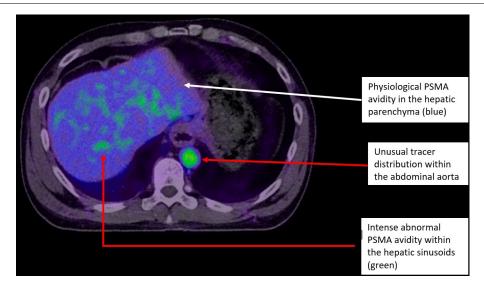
An axial section of AM's PSMA PET scan demonstrating intense tracer presence (green) within the hepatic sinusoids, abdominal aorta and inferior vena cava. There is also less intense, likely background physiological uptake (blue) by the hepatic parenchymal tissue.
